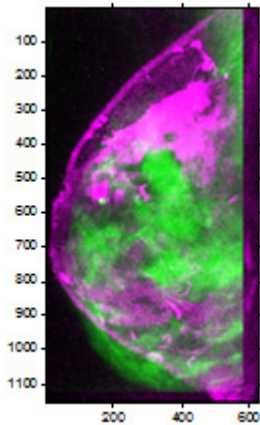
Combined mammography and MRI.
